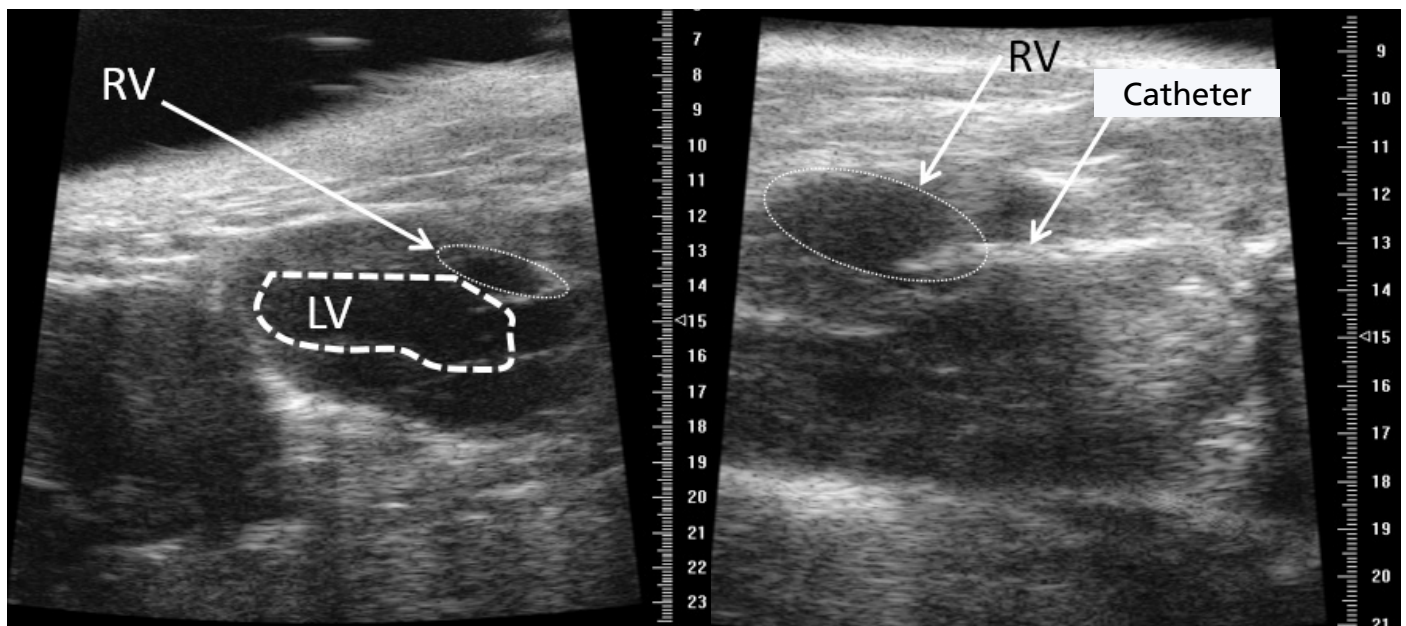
(a) Long axis echocardiography image. LV and RV are encircled (b) The scan head is repositioned to better visualize the RV for catheter insertion.
